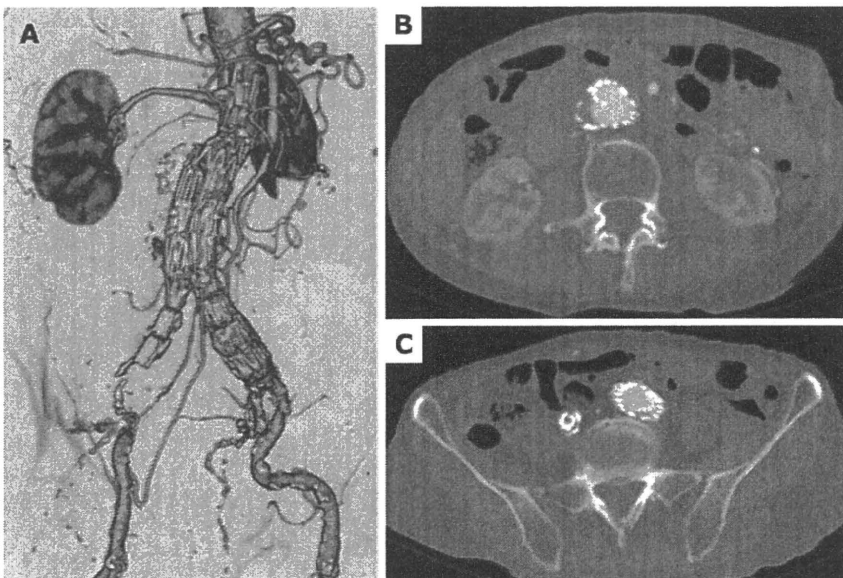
The most recent CT revealed right graft limb occlusion (A) from the flow divider at the bifurcation of the aortic endograft (B) to the external iliac artery (C)
